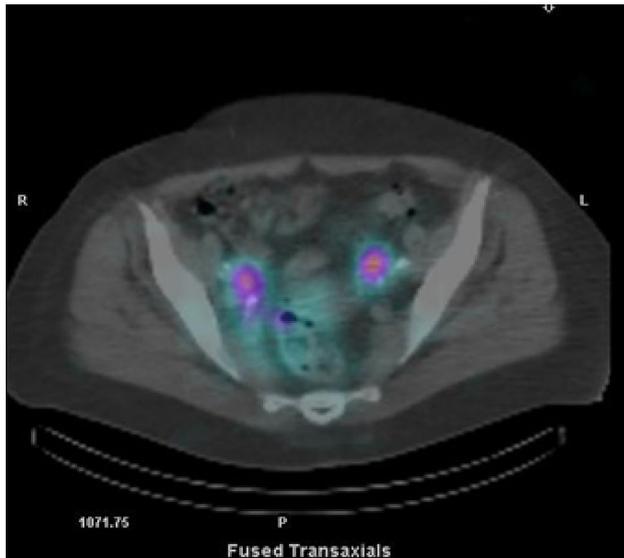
SPECT–CT showing bilateral tracer migration and anatomic location of the SLNs after intracervical injection of Tc-99m
